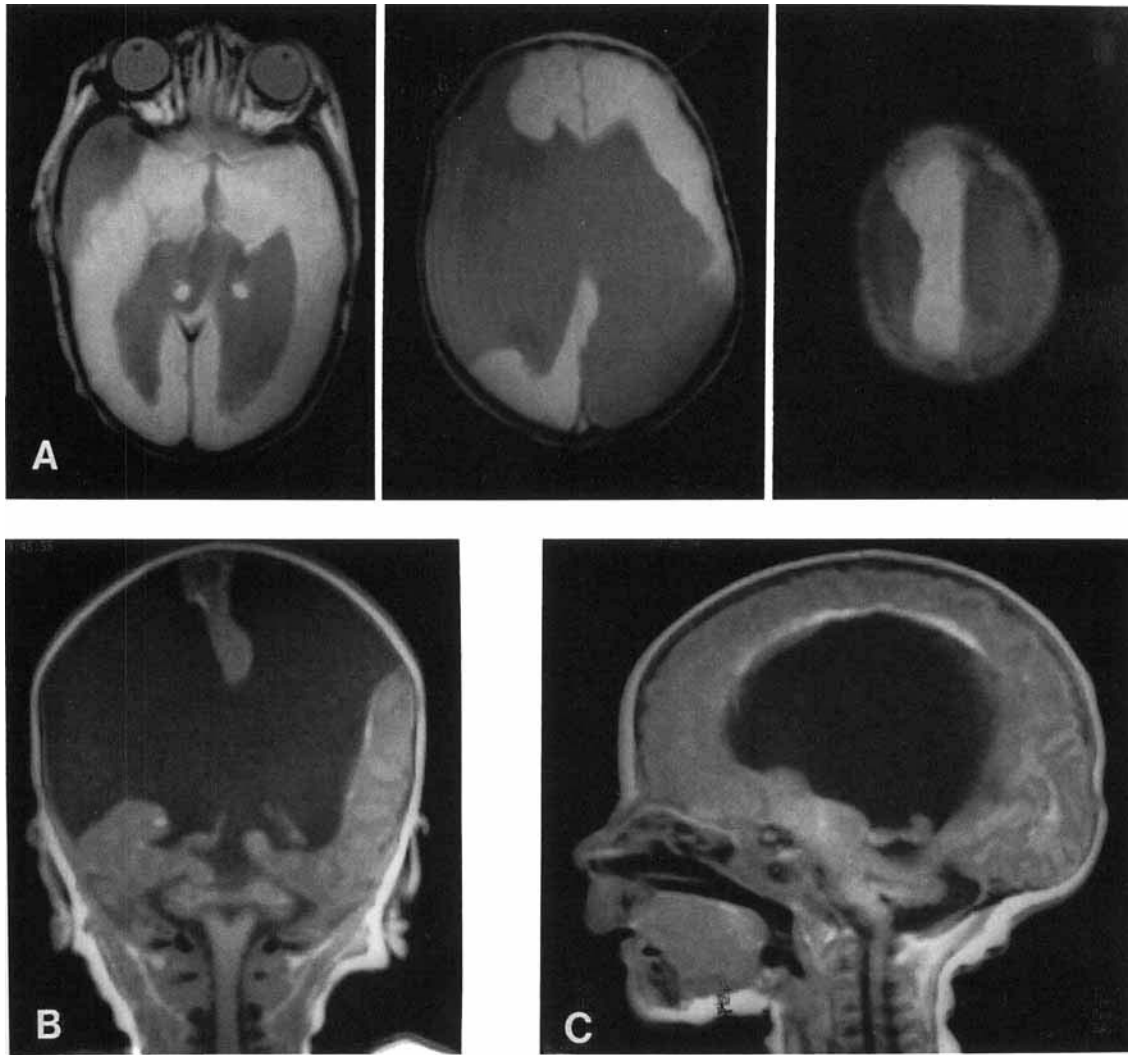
Axial (a), coronal (b), and sagittal (c) T1-weighted magnetic resonance images of the brain, patient 2. Note bilateral hemispheric defects with enlarged ventricles, absence of the septum pellucidum, and cerebellar hypoplasia with aplasia of the vermis, but without cystic expansion of the posterior fossa. Also note preservation of parasagittal tissue on the coronal image (b).
